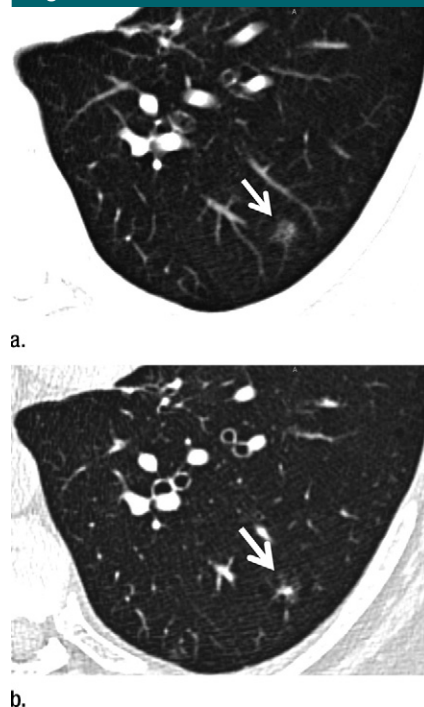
(a) Transverse 5-mm CT section shows an apparently pure ground-glass nodule in the left lower lobe (arrow). (b) Transverse 1-mm CT section at the same level as a reveals that this is a suspicious part-solid nodule with cystic components (arrow).
